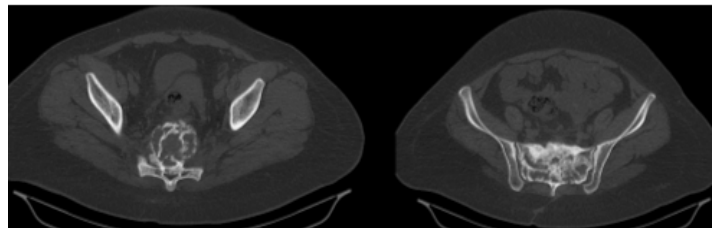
CT of a bone window after 1 year from definitive radiotherapy up to TD 64 Gy combined with targeted therapy.
